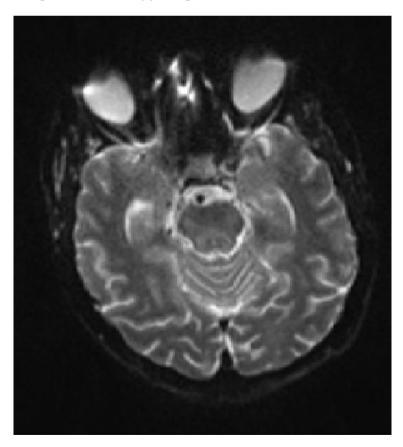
MRI brain image showing evidence of HIE involving bilateral basal ganglia
